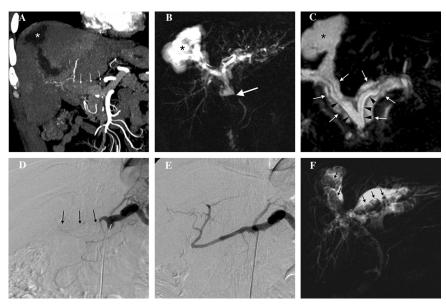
Ischemic cholangiopathy following occlusion of the hepatic artery 8 months after liver transplantation in a 52-year-old patient. A Coronal MIP CT image showing an occlusion of the hepatic artery (arrows) and an intrahepatic biloma (asterisk). B MR cholangiogram showing an irregular dilatation of the donor biliary tract, extending to the anastomosis and sparing recipient biliary main duct (arrow). C 3D-MRCP image showing the abnormal bile ducts (black arrowheads), surrounded by periportal fluid (white arrows).
